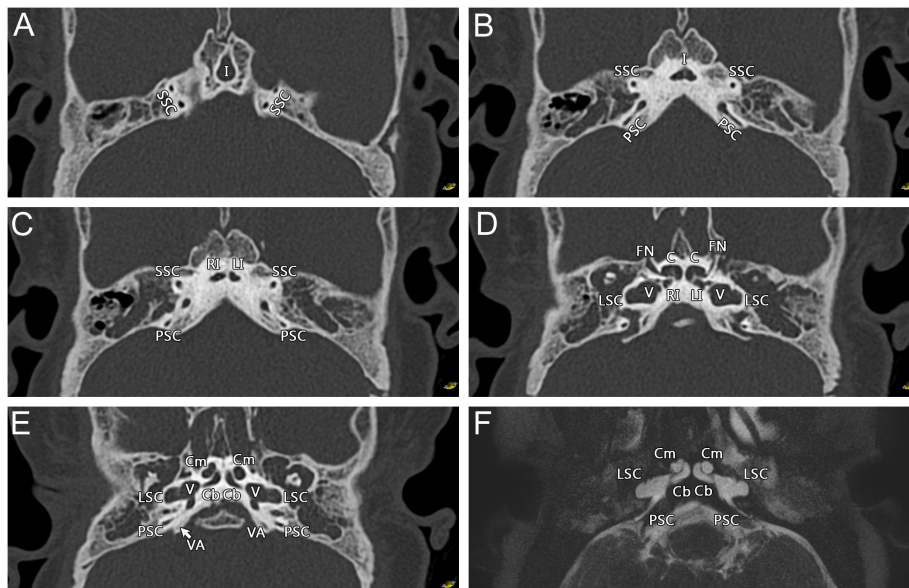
Serial axial images of temporal bone CT from superior to inferior: (A) Level where the internal acoustic canal (IAC) is observed singly in the midline. (B) Level where the IAC is divided into right and left. (C) Levels of the right and left IAC. (D) Vestibular level. Vestibules are dilated bilaterally, and lateral semicircular canals appear cystically dysplastic. The facial nerve canal is observed bilaterally but notably narrow on the left. (E) Cochlear level. Cochlear structures are nearly normal in size bilaterally, but the basal turns of the cochlea are slightly smaller. On the right, the middle turn is present but blind-ended, and the apical turn is not visualized (1.5 turns). On the left, the middle turn terminates after slight expansion. (F) Serial axial images of temporal bone CT from superior to inferior: MIP view of MRI passing through the cochlear level. Abbreviations: C, cochlea; Cb, cochlear basal turn; Cm, cochlear middle turn; CN V, cranial nerve V (trigeminal nerve); FN, facial nerve canal; I, internal acoustic canal; LI, left internal acoustic canal; LSC, lateral semicircular canal; PSC, posterior semicircular canal; RI, right internal acoustic canal; SSC, superior semicircular canal; V, vestibule; VA, vestibular aqueduct.
